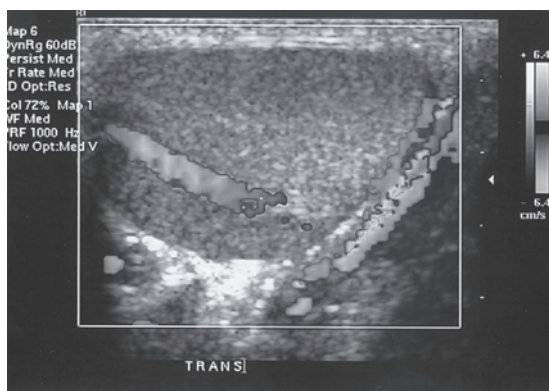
Normal testicular vascular flow. Color Doppler shows normal flow both within testicle and on its periphery (see color inserts).
